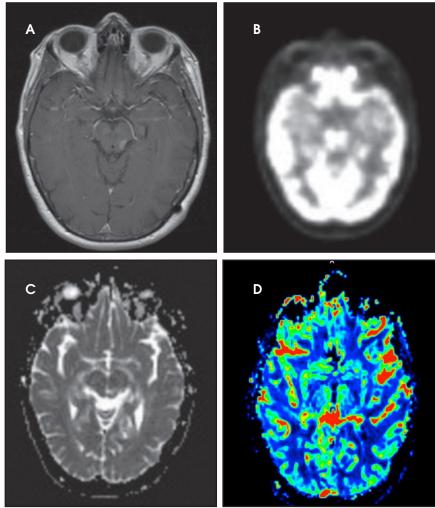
At one month follow up (15 months post-SRS) the lesion was noted to be stable on standard series MRI (A). The treated area was photopenic on FDG-PET (B), demonstrated no decreased diffusion on ADC (C), and was without clear evidence for elevated blood volume in association with this lesion (D). The relative cerebral blood volume assessment was considered to be limited as the left PCA travels in very close proximity to the area of enhancement (within 2 mm) causing substantial increase signal symmetrically about the brainstem related to the arterial enhancement.
